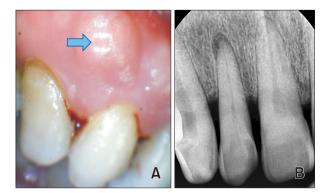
(A) A gingival swelling and fistula located around the right maxillary lateral incisor at the initial visit (arrow). (B) The initial x-ray of the related tooth. Small apical radiolucency was seen at the root apex, but no definite horizontal root fracture was detected.
